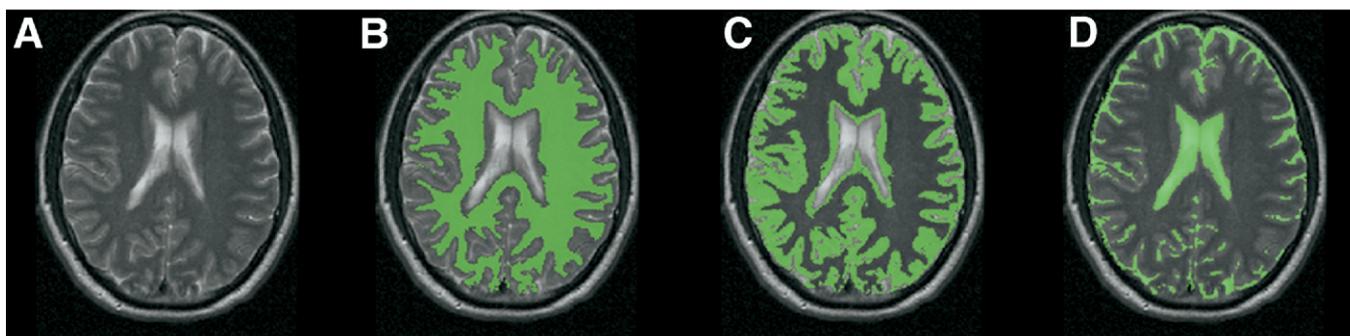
Segmentation technique used to calculate standardized uptake values in gray matter, white matter, and CSF fluid. One slice of intensity inhomogeneity corrected and intensity standardized T2-weighted image is shown in (A). (B-D) Overlap between slice in (A) and corresponding slice of segmented WM, GM, and CSF, respectively. (Image courtesy of Jay Udupa, PhD.)
